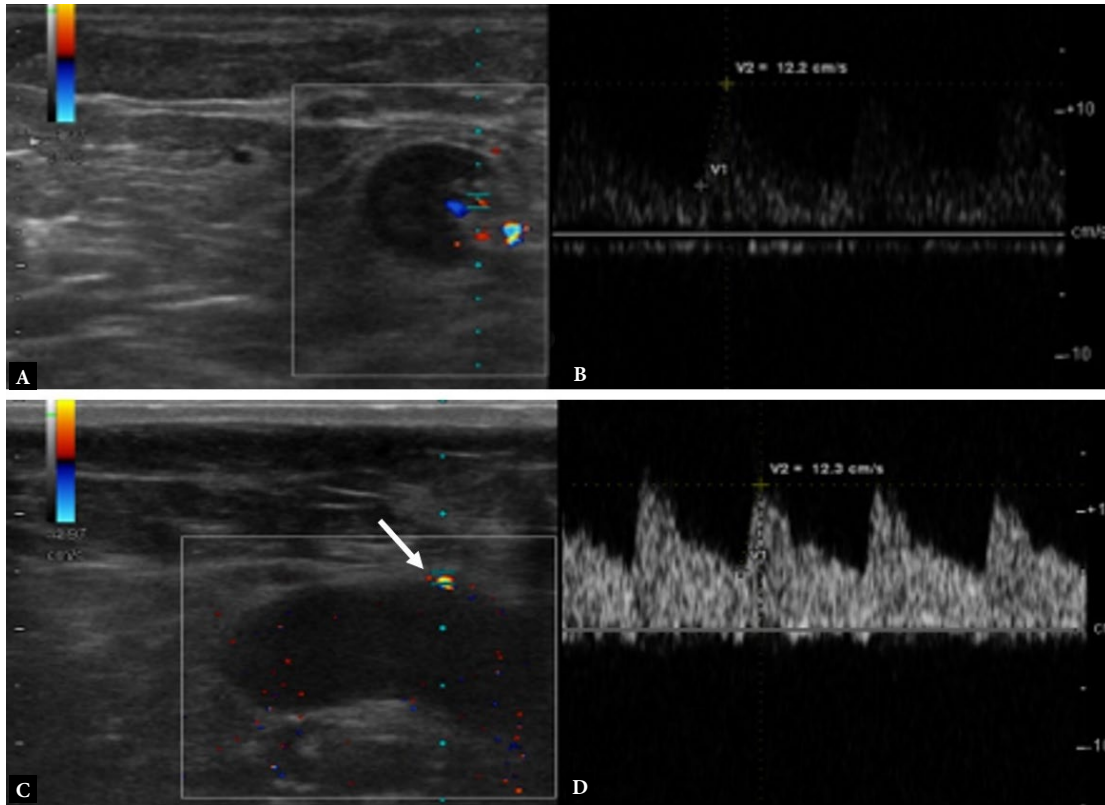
On Doppler US, A. color and B. spectral Doppler examination of the lymph node with hilar blood supply is shown. On Doppler US, A. color and B. spectral Doppler examination of obliterated hilus lymph node with peripheral blood supply and asymmetric cortical thickness is seen
